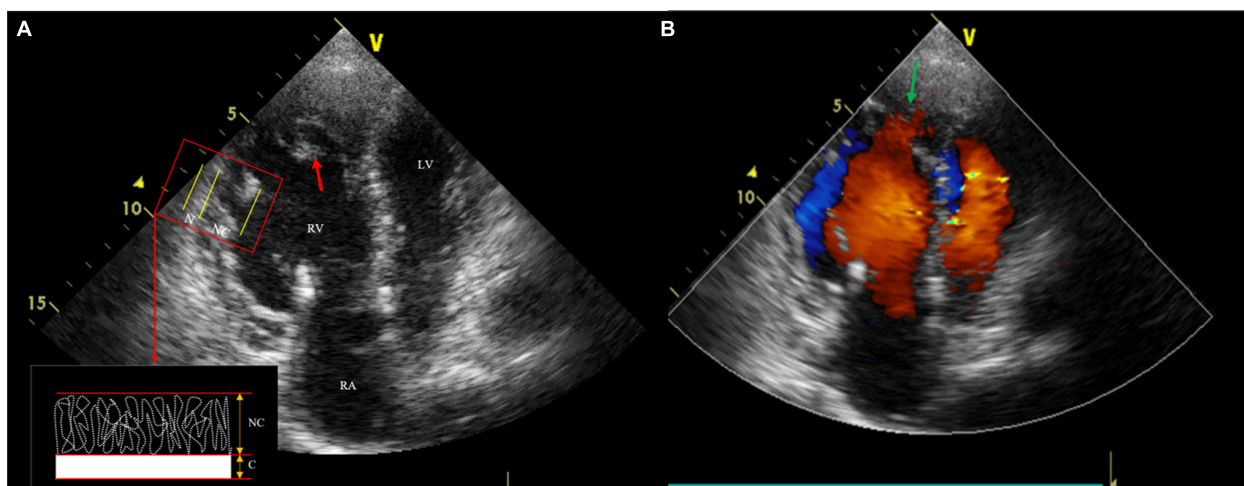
Transthoracic echocardiography (TTE) shows three anatomical components, including thin compacted layer, prominent intracardiac trabeculae (the red arrow) and deep intertrabecular recesses. The measured ratio of non-compacted to compacted myocardium was 2.7:1 (A); Color Doppler echocardiography reveals deep recesses communicated with the Right ventricle (RV) cavity (the green arrow) (B).
